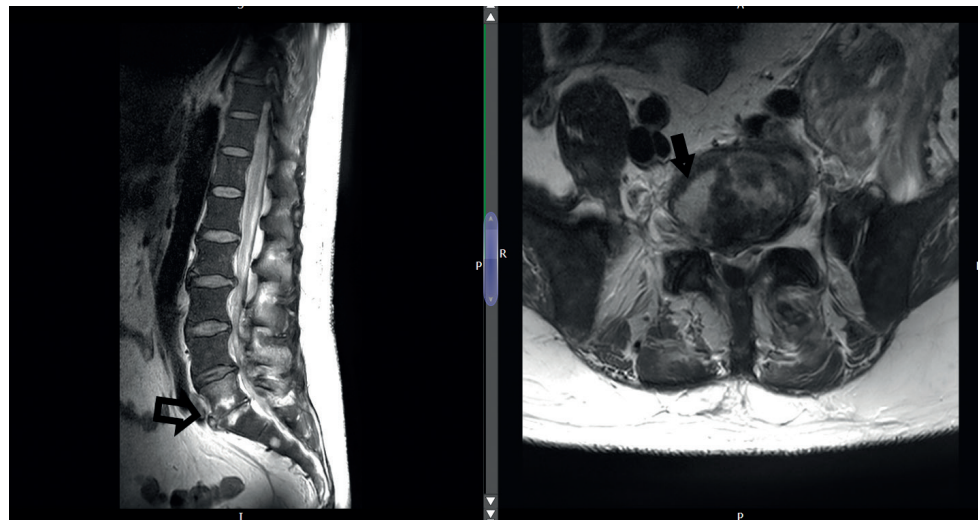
T2-weighted magnetic resonance imaging showing (a) a sagittal view of the lumbar spine demonstrating high signal in the end plates of the L5 and S1 vertebrae with (b) an axial image at the same level demonstrating high signal within the L5–S1 intervertebral disc.
